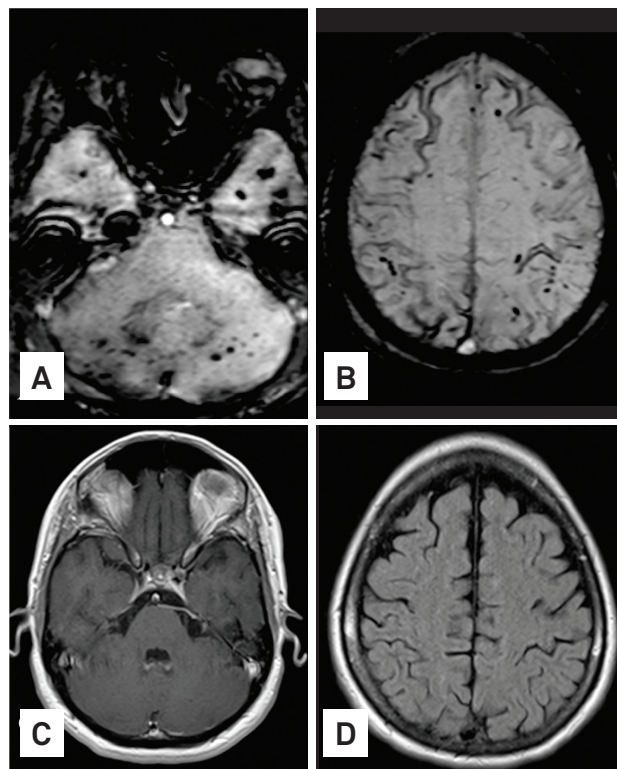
Susceptibility-weighted imaging showing the posterior fossa (A) and at the skull convexity (B) demonstrate multiple foci of low signal intensity on the subcortical white matter and cerebellum, suggesting microbleeds, and linear low signal intensity on the surface of the frontal cortex, compatible with subarachnoid hemorrhage. Post-contrast-T1 weighted image on the same position as A (C) and FLAIR image on the same position as B (D) show no abnormalities. The rest of the exam did not show any sign of aneurysms or meningitis.
